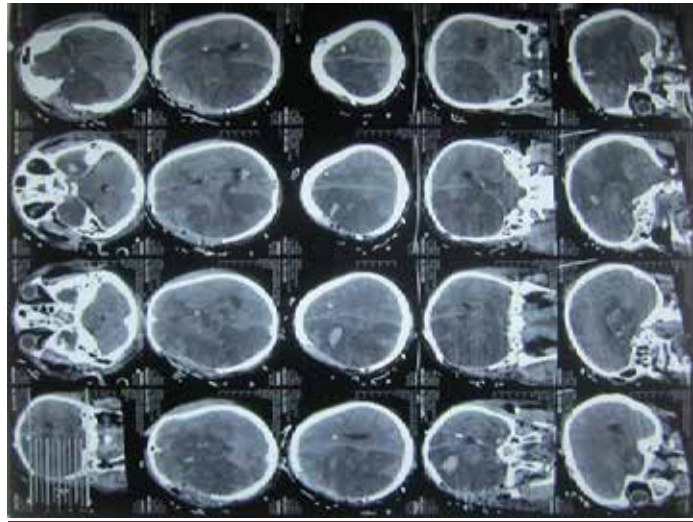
Head CT Scan of postoperative evaluation
